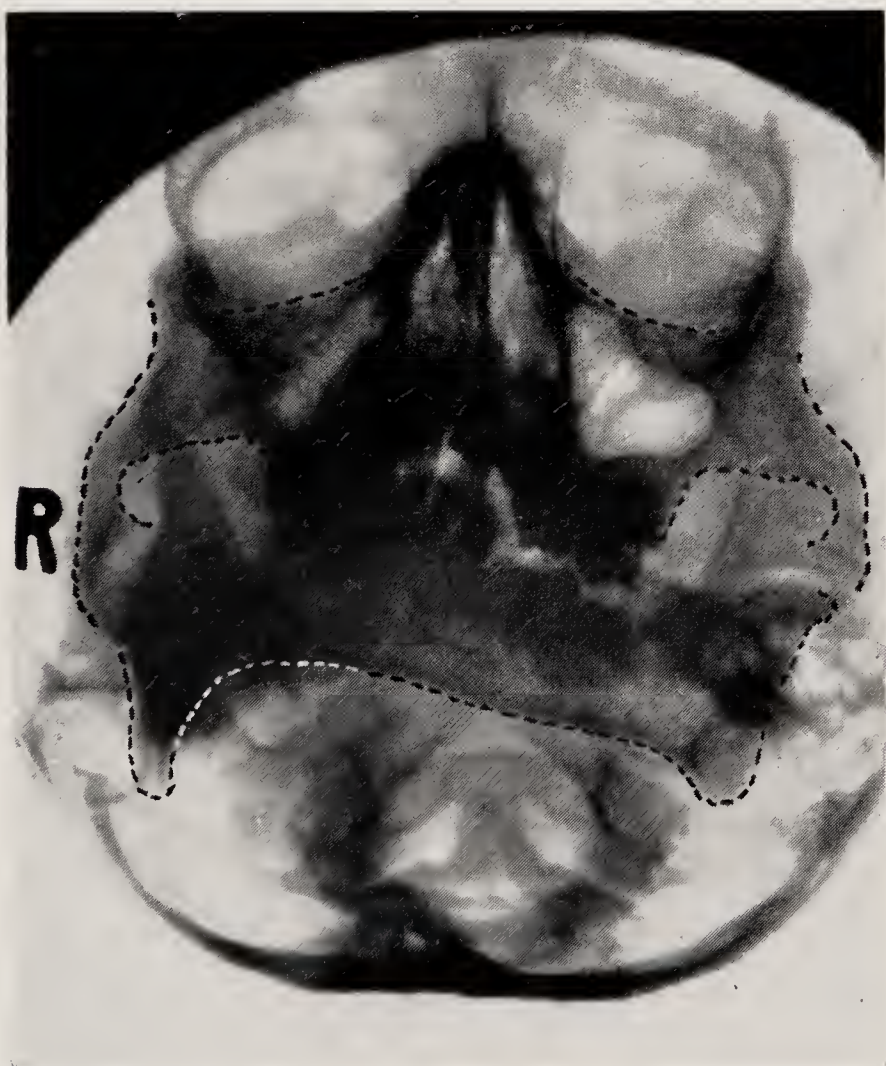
The occipito-mental radiograph shows the changes in the maxilla secondary to a primary lesion of the right condylar growth centre.
